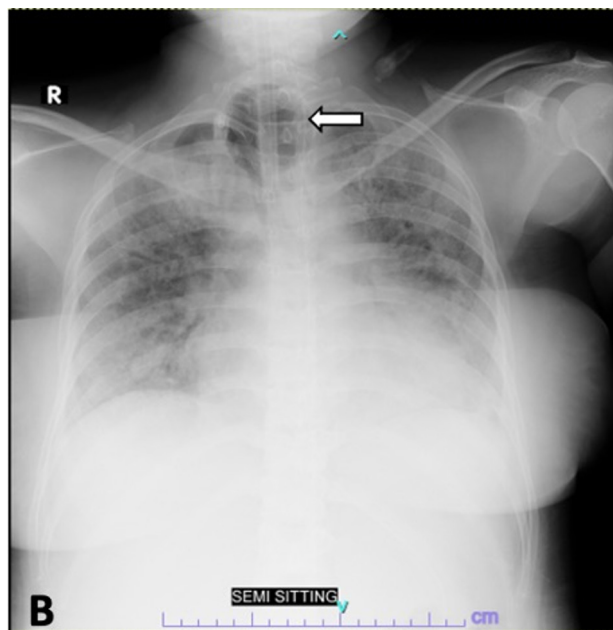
A chest radiograph taken on day 51 of admission, 1 week after tracheostomy. An extended-length tracheal tube (white arrows) is seen extending past the tracheal dilatation, approximating the location of the tracheoesophageal fistula. The black arrow outlines the chest tube inserted into the left hemithorax.
